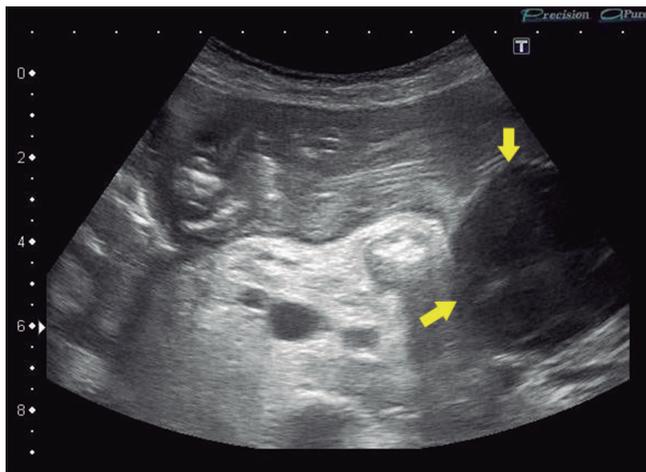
Ultrasound: in an epigastric transverse plane a hypoechoic mass can be seen on the posterior wall of the stomach (arrows).
